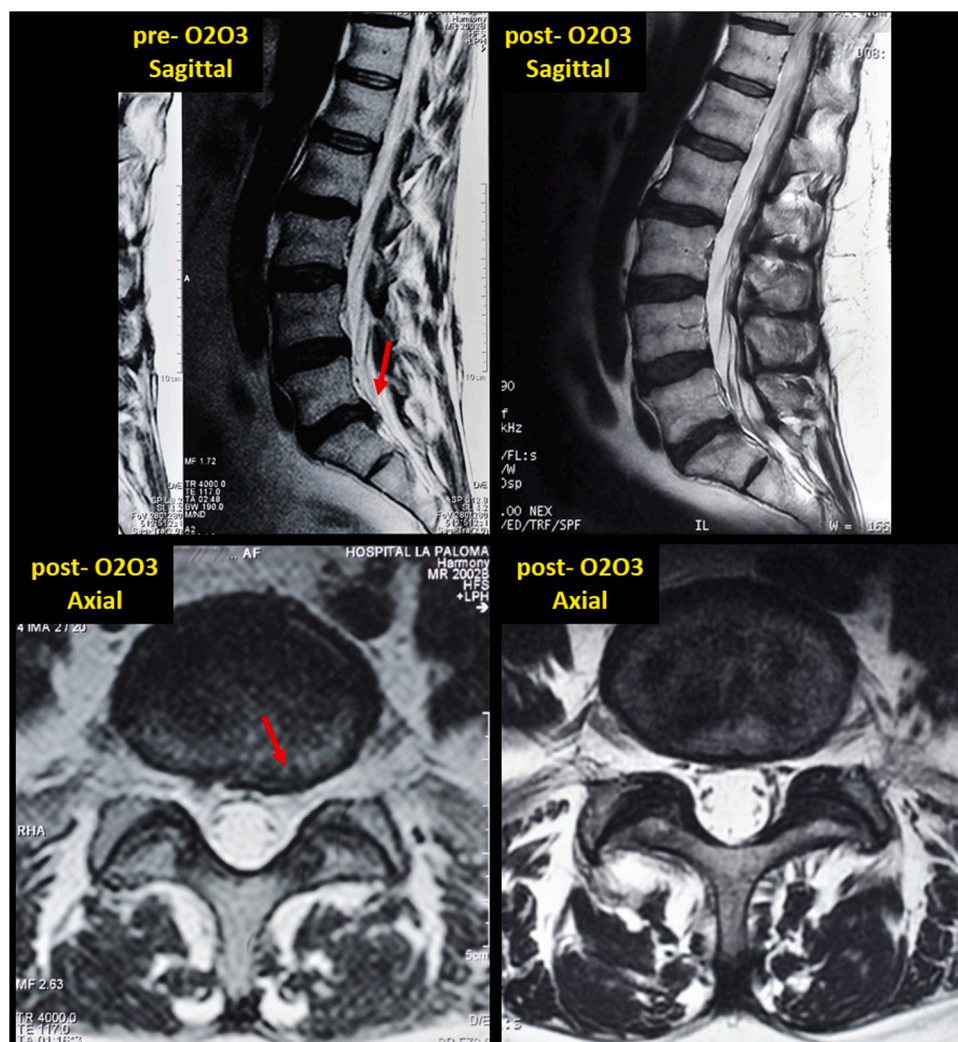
Images pre- and post- ozone treatment. 59 years old patient on waiting list for surgery because a symptomatic, left paramedial L5-S1 disc herniation (red arrows), with small caudal migration, and S1 compression. After randomized, blinded assignment, the patient was treated by intradiscal oxygen-ozone (O2O3) infiltration. Planned surgery was avoided. In the last magnetic resonance images (MRI), nine years after procedure, the patient remained without disc herniation relapse. *Upper Left:* Sagittal MRI pre-treatment. *Upper Right:* MRI three years post-treatment. *Lower Left:* Axial MRI pre-treatment. *Lower Right:* Axial MRI three years post-treatment.
